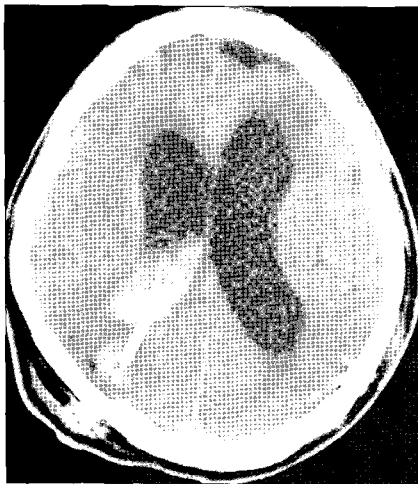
The first postoperative brain CT showing the development of the focal intracerebral hemorrhage in the right parietal lobe, intraventricular hemorrhage and subcutaneous hematoma in the posterior nuchal scalp following ventriculoperitoneal shunt tract.
